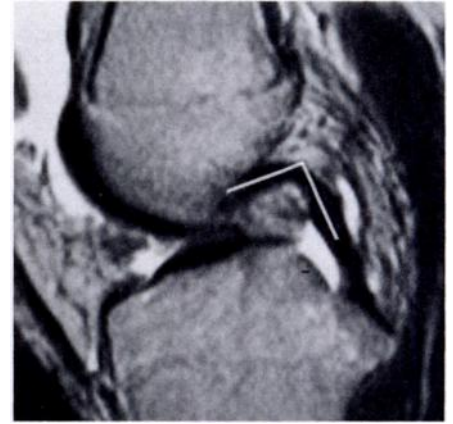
Sagittal (2,000/80) MR image of a 35-year-old man with ACL tear at arthroscopy. The PCL angle measured between a line through the center of the proximal portion of the PCL and a line through the center of the distal portion of the PCL is 96° .
